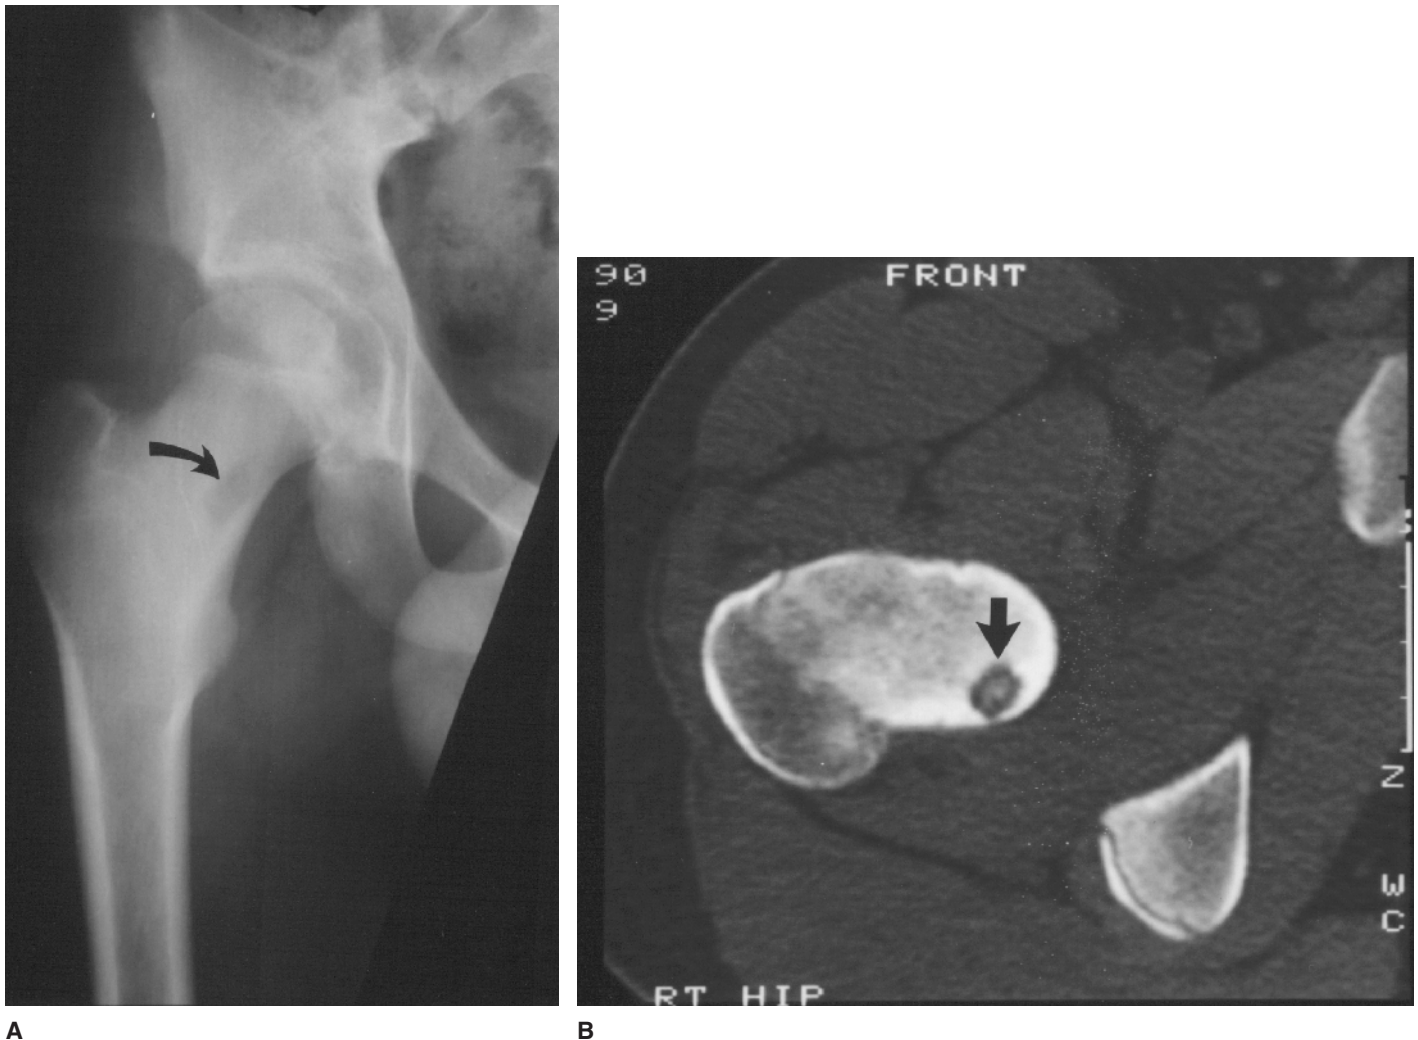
(A) Anteroposterior radiograph of the right hip in a 14-year-old boy demonstrates an ovoid radiolucency in the medial aspect of the right femoral neck (arrow). (B) Thin-section axial CT image demonstrates an osteoid osteoma of the posteromedial right femoral neck. There is some mineralization in the center of the radiolucent nidus (arrow).
